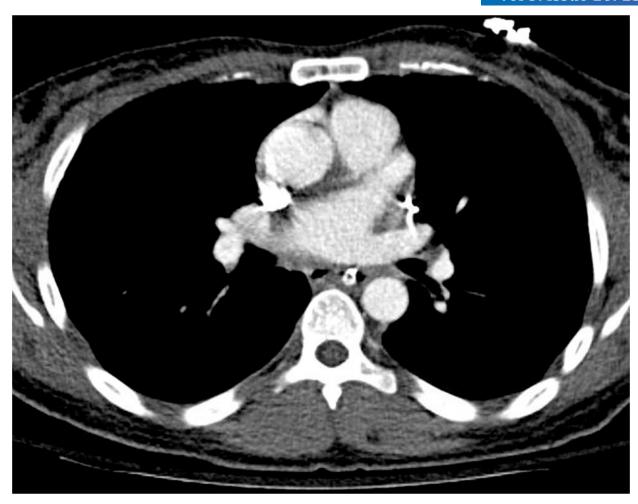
CT axial, IV Contrast in the Right SVC and Central Line in the Left SVC
